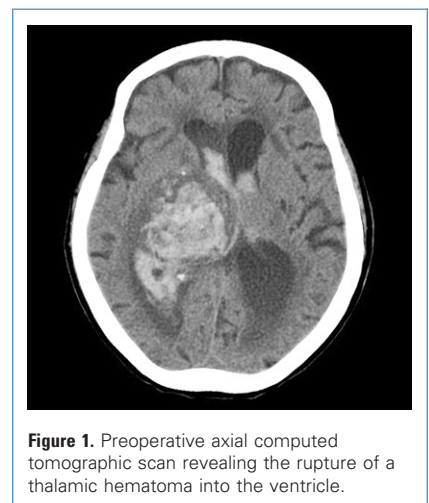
Preoperative axial computed tomographic scan revealing the rupture of a thalamic hematoma into the ventricle.
